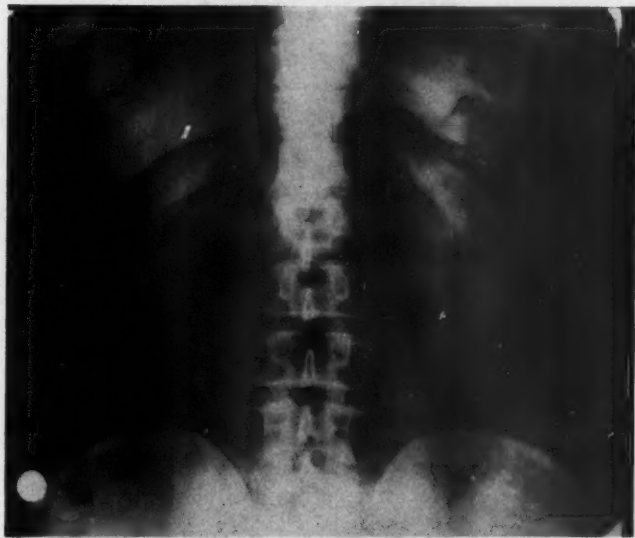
Air injection x-ray of man of 40 with obesity, atrophy of the testis and psychologic changes. Showing bilateral enlargement of the adrenals. No operative procedures done.
